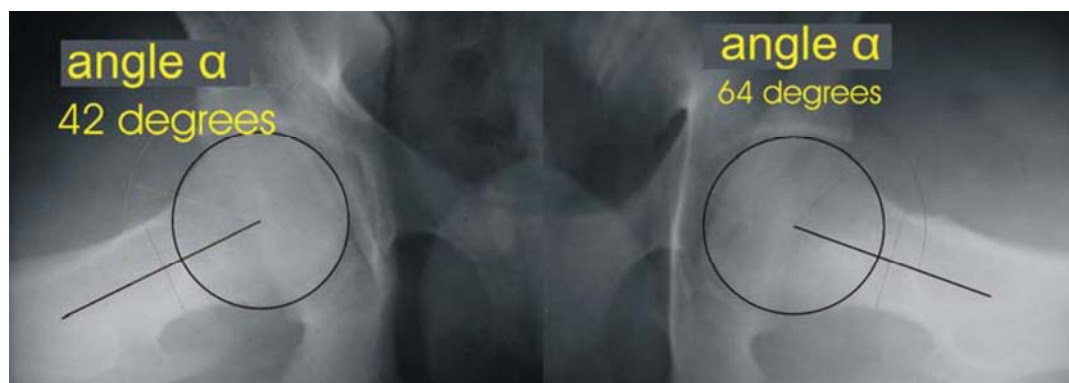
Standardized profile Dunn-Rippstein-Müller x-ray images of the hips: the left hip (right picture) – angle α 64°; the right hip (left picture) – angle α 42°.
